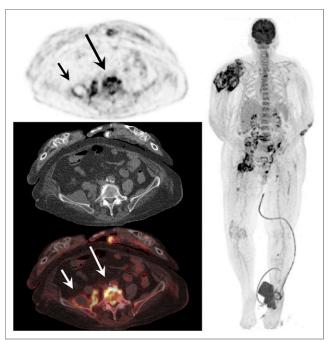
¹⁸F-FDG PET/CT images of 84-y-old woman with rightsided closed humerus fracture after a fall. Two weeks later, she developed arthritis of her left metacarpophalangeal joints and blood cultures were positive for methicillin-susceptible *S. aureus.* Transesophageal echocardiography was negative for endocarditis. Besides arthritis of her left metacarpophalangeal joints, ¹⁸F-FDG PET/CT also showed metastatic infection in her right hip prosthesis, left ankle, right humerus with surrounding abscesses, and lumbar spine (L4–L5) with a right psoas abscess. This patient underwent CT-guided drainage of psoas abscess and was treated with cephazolin, because of allergy to flucloxacillin.
